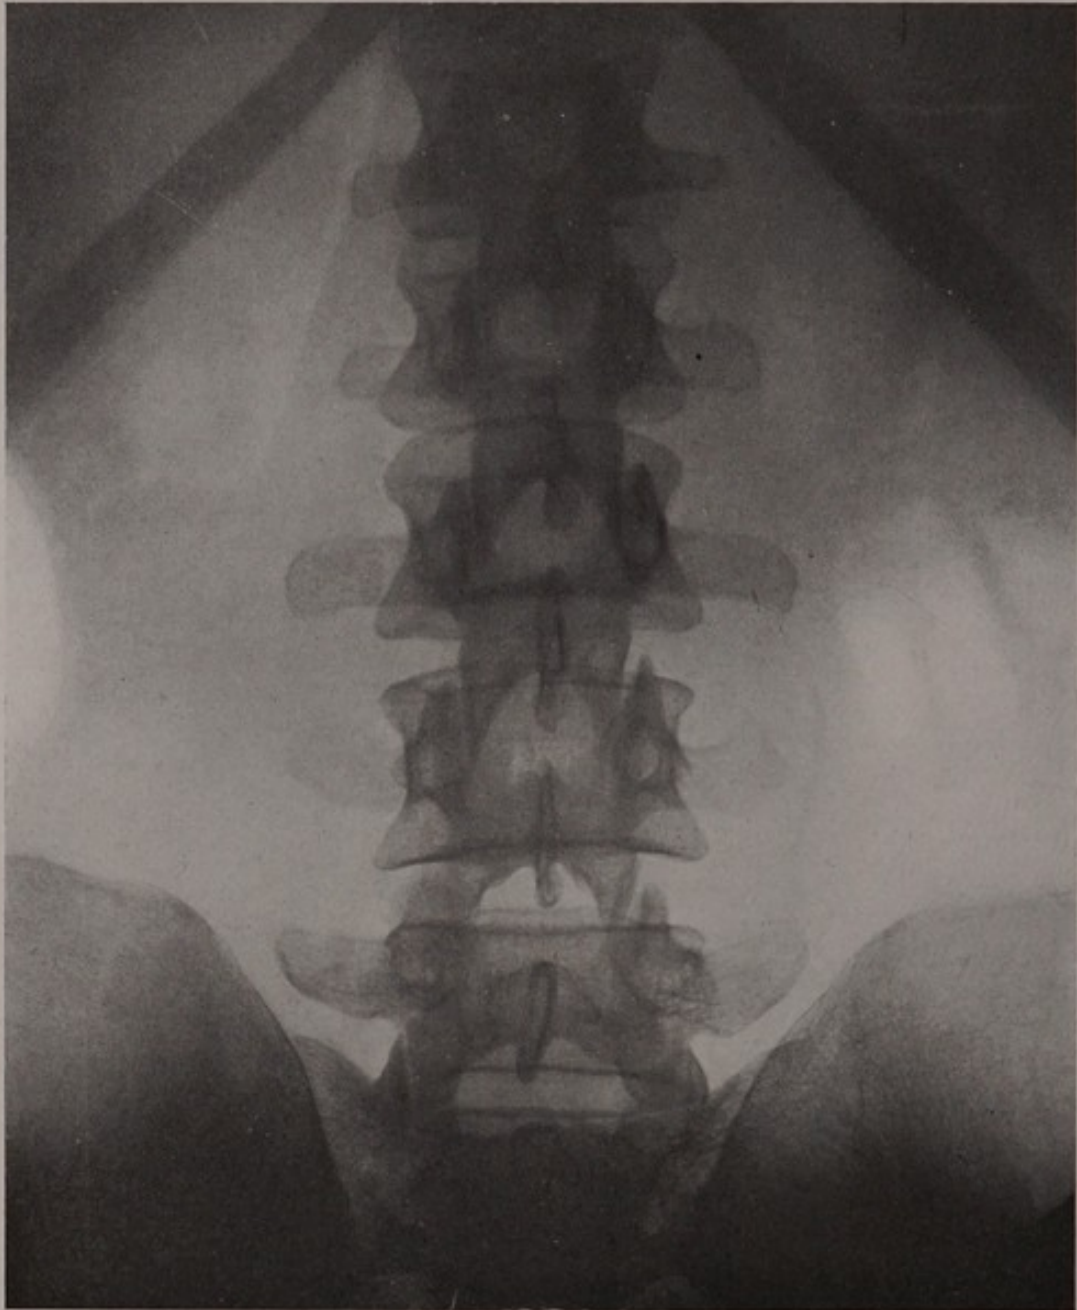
X-ray of the lumbar vertebræ.
